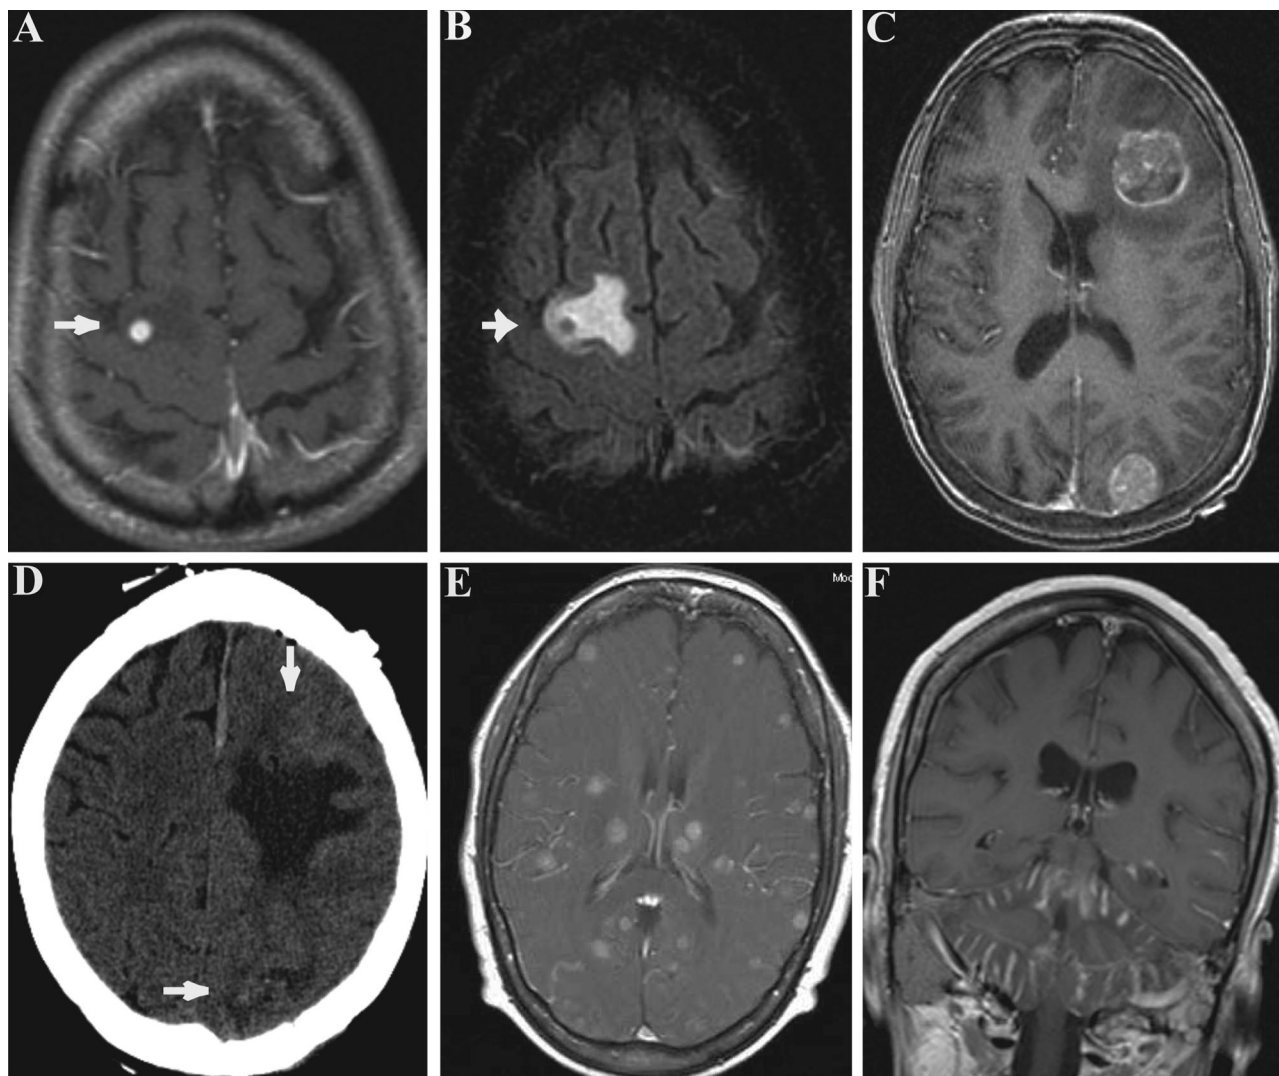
Representative manifestations of breast cancer metastasis to the brain. A: Solitary metastasis (~1 cm in size) to the brain demonstrated by MRI (T1-weighted, axial, postgadolinium image). The tumor is in the posterior right frontal lobe. B: The tumor (arrow) is surrounded by a significant amount of peritumoral edema (T2-weighted axial MR image). C and D: Multiple metastasis to the brain before (C) [demonstrated by MRI (T1-weighted images with the administration of gadolinium for contrast)] and after (D) surgical resection (axial computed-tomography scan with contrast; arrows in D indicate the location of the resection). The tumor in the left frontal region was intraparenchymal and the tumor in the left parieto-occipital region was dural-based. E: Miliary metastases demonstrate multiple, contrast-enhancing lesions on a single T1-weighted, gadolinium-enhanced MRI slice, ranging in size from 2 to 3 mm to 1 cm. F: Carcinomatous meningitis. Multiple linear enhancing tongues of tumor can be seen outlining the cerebellar folia on the T1-weighted gadolinium-enhanced MRI.
